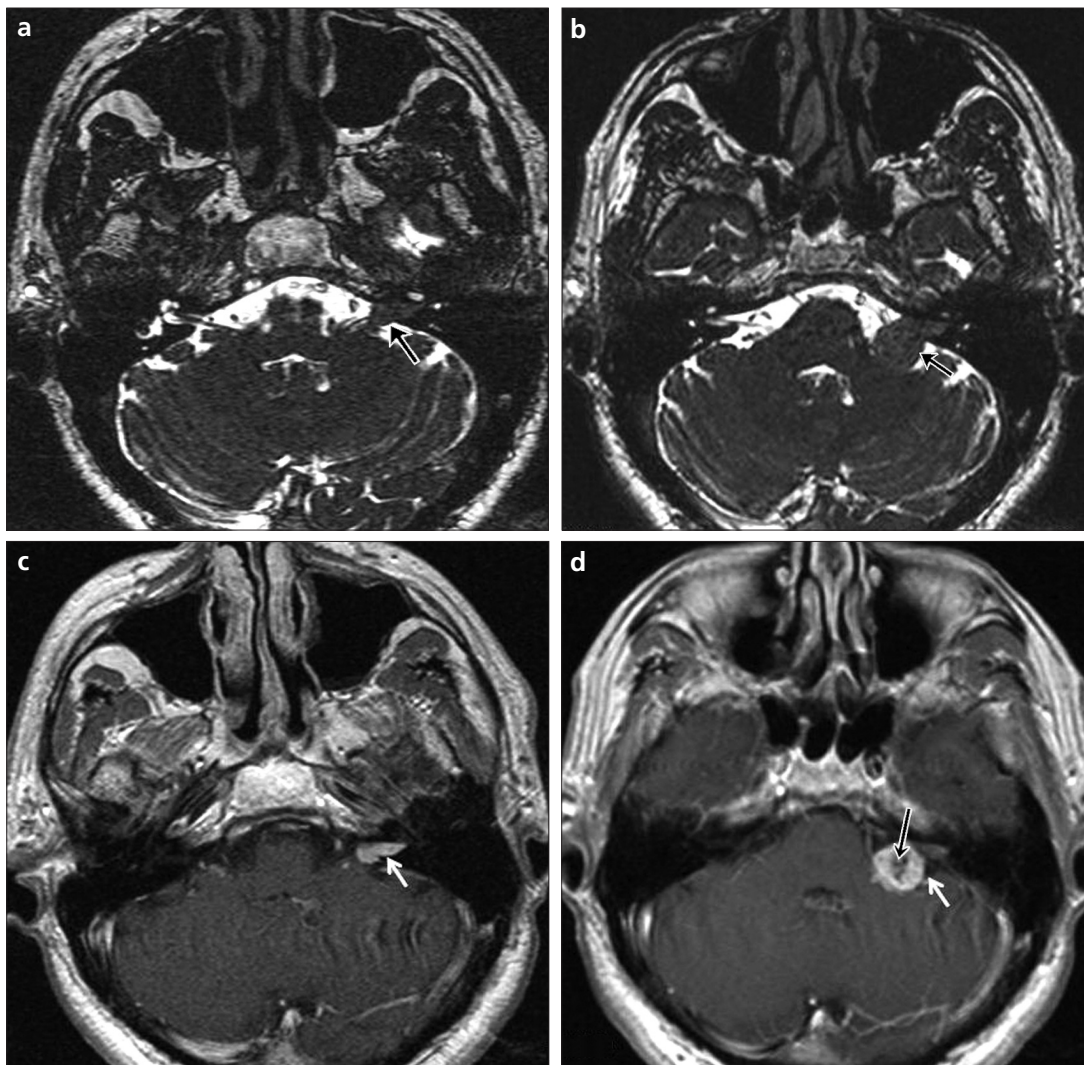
a–d. Axial CISS sequence (a) shows a vestibular schwannoma in the left internal acoustic canal (black arrow). The follow-up MRI examination (b) 22 months later, shows that the size of the tumor has increased (black arrow). Contrast-enhanced T1-weighted MRI sequences (c, d) demonstrate the change in size (white arrows). Additionally, cystic changes that developed in the follow-up period can be detected in this sequence (d, black arrow). This internal structural change cannot be seen in the CISS sequence.
